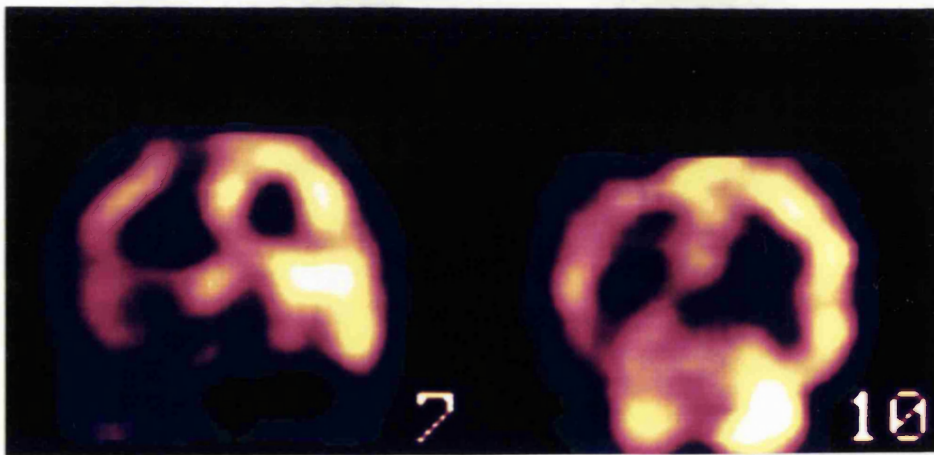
MRI, inversion recovery, transverse and coronal sections (A) and interictal  $^{99}\text{Tc}^m$  HMPAO SPECT scan (B) from patient T4. The MRI shows left hippocampal sclerosis with signal change within the temporal lobe. Interictal SPECT shows hypoperfusion not only of the temporal lobe but also into the frontoparietal regions.
